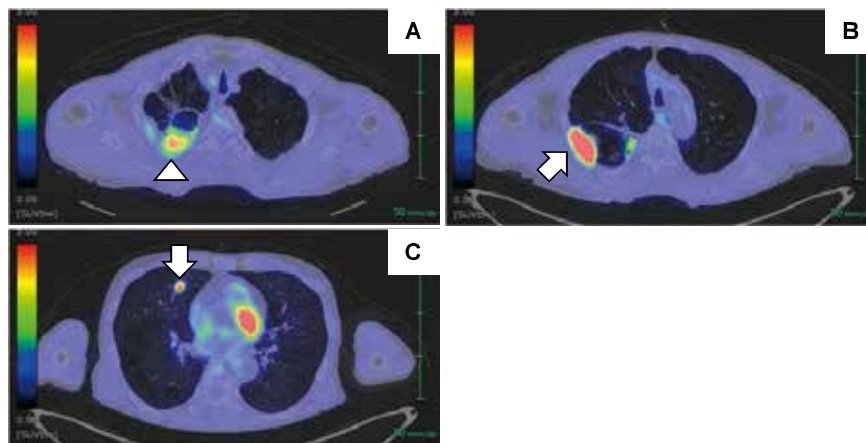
Findings of PET/CT scan on admission. A PET/CT scan revealed high uptakes in a cavity in the apex of the right lung (A), a mass in the right upper lobe (B) and a nodule in the right middle lobe (C), with SUVmax of 4.9, 16.2 and 6.8, respectively. Arrowhead and arrows indicate the locations of pulmonary *M. heckeshornense* infection and lung adenocarcinoma, respectively.
